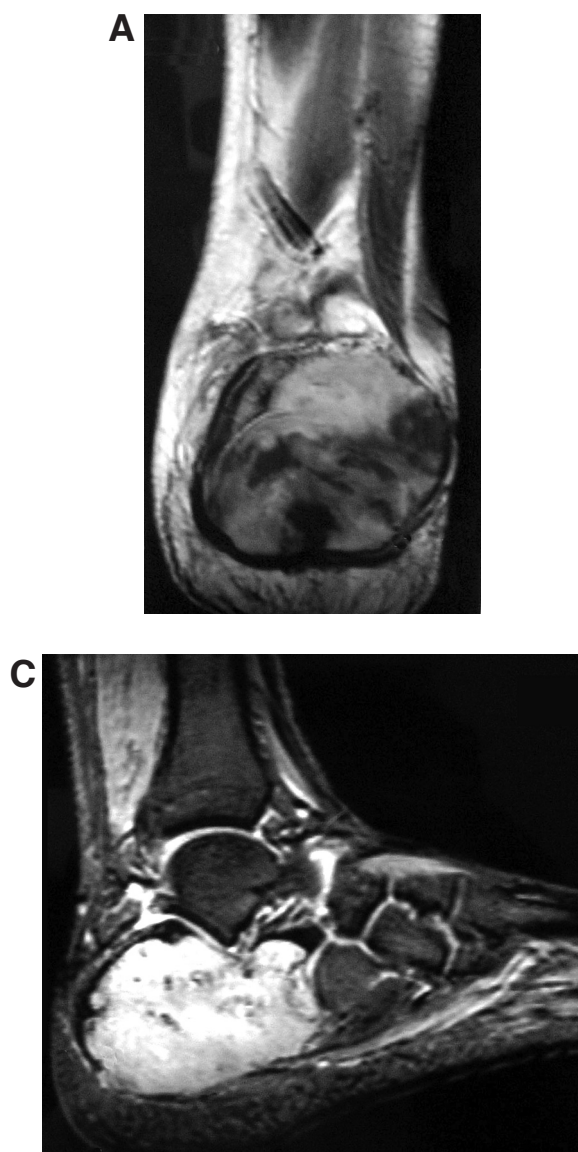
A, The inferolateral aspect of the talus and cuboid bones was hypointense on T1-weighted magnetic resonance images. B, The talus and cuboid bones were hyperintense on T2-weighted images with fat suppression. C, After paramagnetic contrast fluid injection, there was a contrast view of the lesion.
